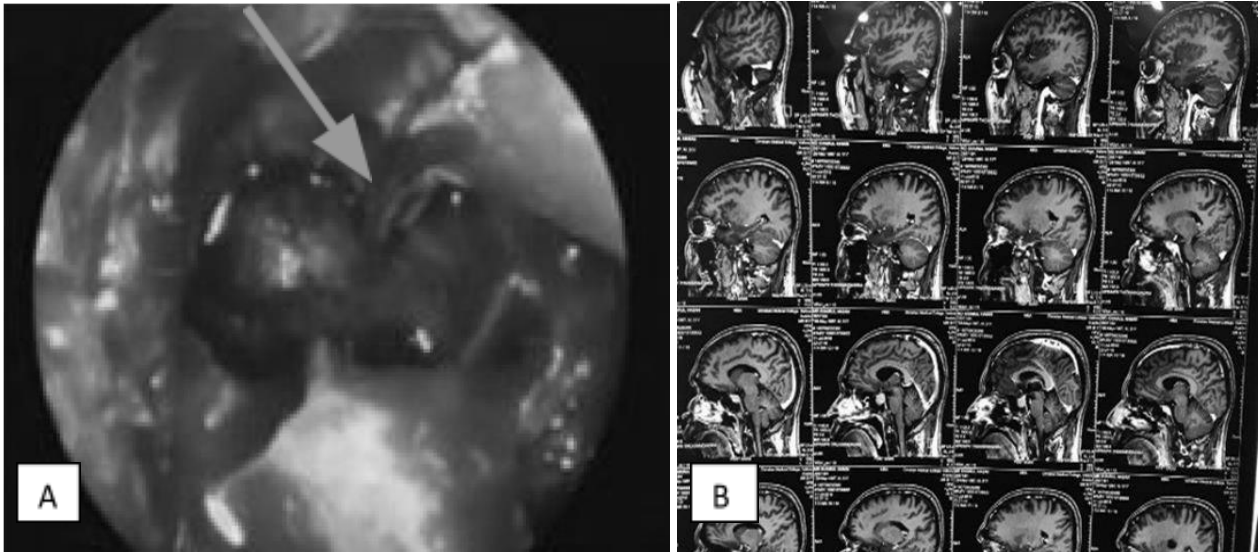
(A, B). Intraoperative image and MRI image of recurrent pituitary tumour.
